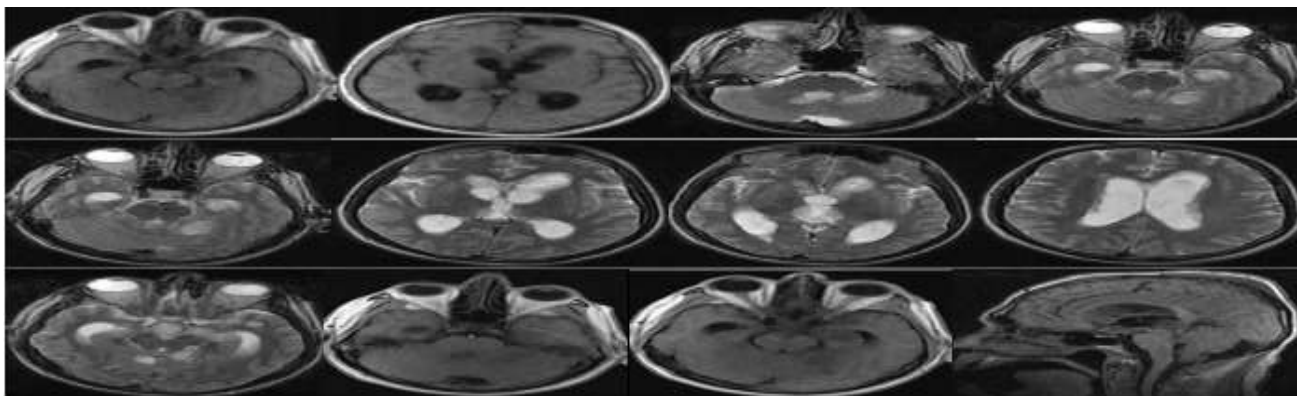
Multiple axial & sagittal T1/T2 WI brain MRI of 60 year old patient with GC
